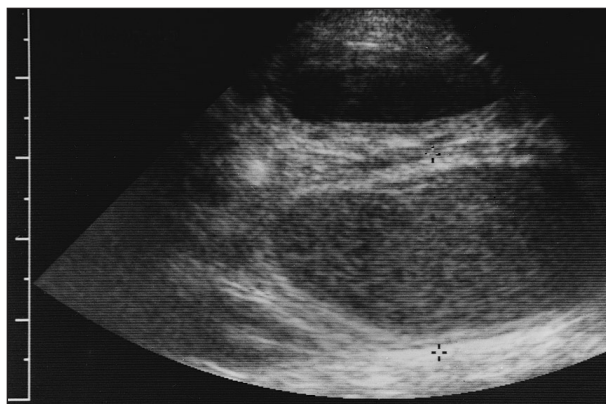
Ultrasonogram of the uterus of a 4-year-old sexually intact female Gordon Setter that had been mated 17 and 19 days preceding the examination. Marks on scale on left side are at intervals of 5 mm. Distance between asterisks is 24.6 mm.
